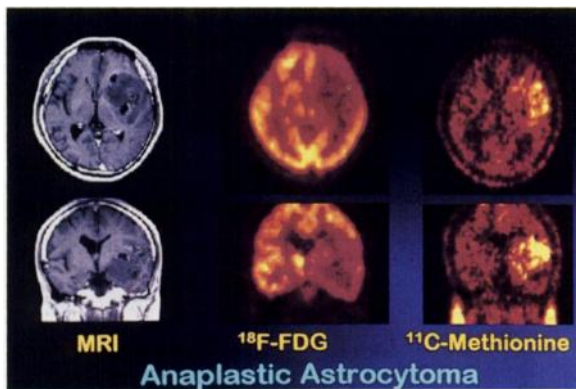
Better visualization of a brain tumor with ^{11}C methionine, compared with FDG, which accumulates in normally functioning brain (#271).
